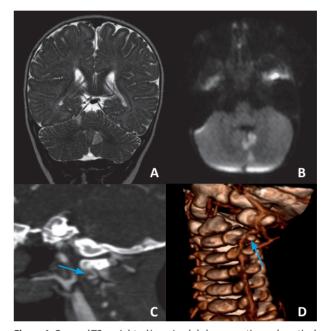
Coronal T2-weighted imaging (a) shows cortico-subcortical lesions in both cerebellar hemispheres, well-defined and with slight expansion. Axial diffusion-weighted imaging (b) reveals the reduced diffusion of the left hemispheric lesions, compatible with acute ischemia. Computed tomography angiography (c, d) depicts focal fusiform dilation in the V3 segment of the left vertebral artery, suggesting small dissecting pseudo-aneurysm (arrows).
